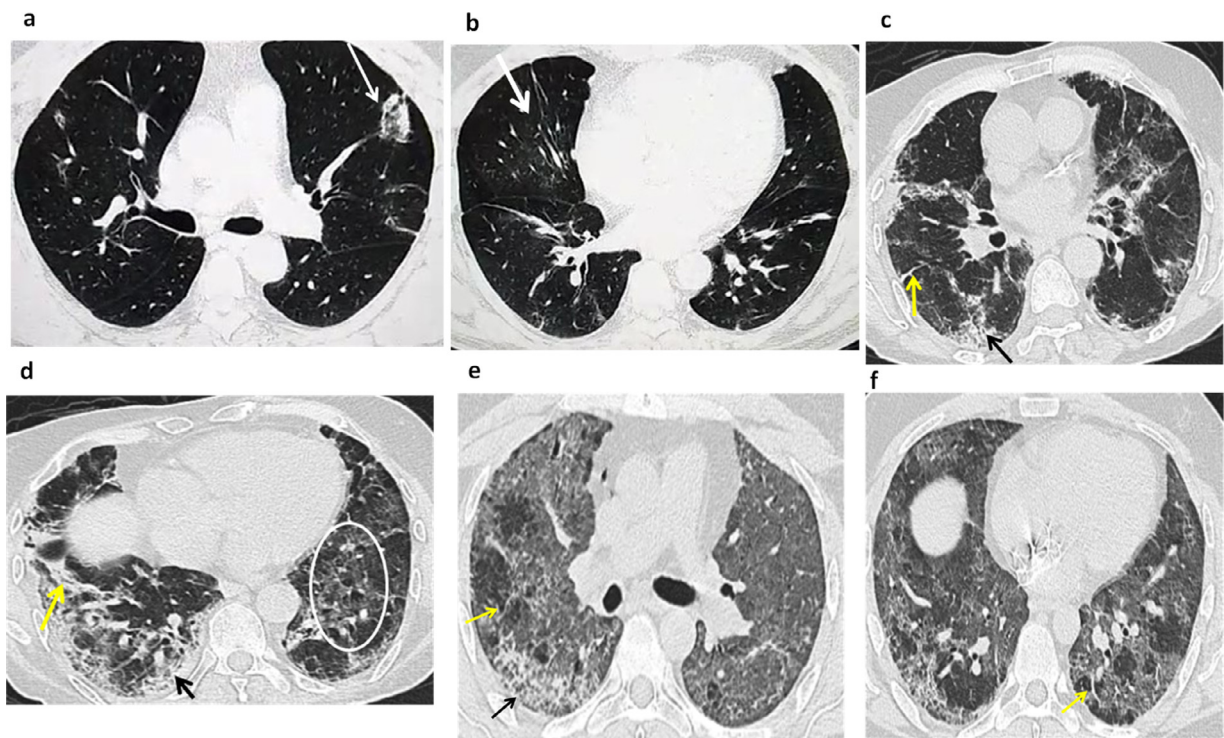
Residual CT findings in recovered patients. (A,B) Axial CT chest in a 59-year-old Post COVID-19 patient with residual symptoms reveals (A) reverse halo sign (arrow) and (B) bronchiectasis (arrow). (C,D) Axial CT chest in a 75-year-old Post COVID-19 patient with residual symptoms reveals resolving bilateral subpleural GGO (encircled D), reticular opacities, fibrotic bands (yellow arrows C,D), and subpleural honeycombing (black arrow C,D) in bilateral lower lobes, representing post-COVID fibrosis (E,F) Axial CT chest in a 34-year-old COVID-19 recovered patient with residual symptoms reveals bilateral widespread residual GGO, peripheral reticular opacities, fibrotic bands (yellow arrows E, F), subpleural honeycombing in right lower lobe (black arrow E) compatible with post COVID fibrosis (Color version of the figure is available online.).
